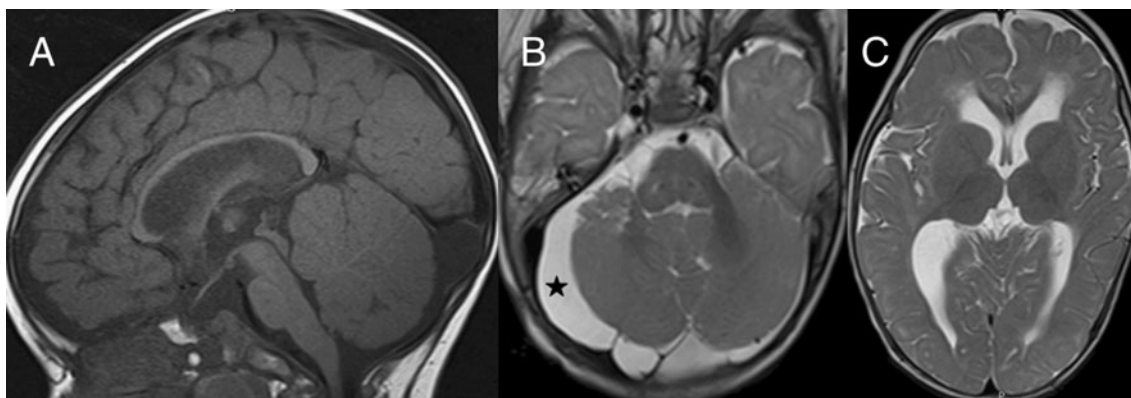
Midsagittal (a) and axial (b) T2-weighted MR images of patient 4 at the age of 10 months show a macrocerebellum with a marked increase of the cerebellar gray matter. Additionally, a size reduction of the fourth ventricle (a), a right paracerebellar arachnoid cyst (black
